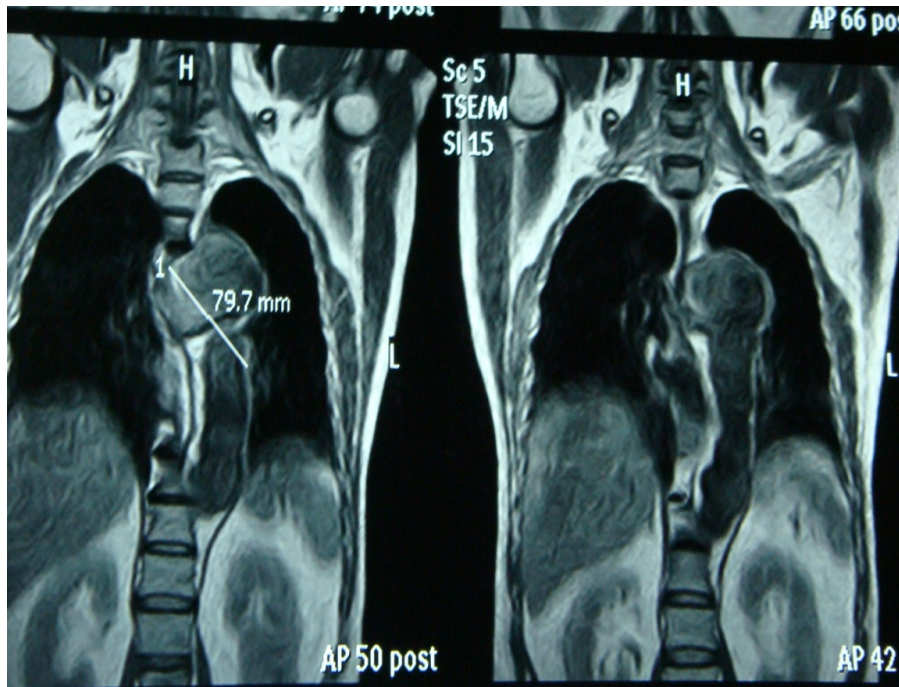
Large saccular aneurysm 10.6-6.4 cm arch of aorta and Descending thoracic aorta aneurysm eroding into the adjacent vertebrae With left minimal pleural effusion (MRI thorax)
